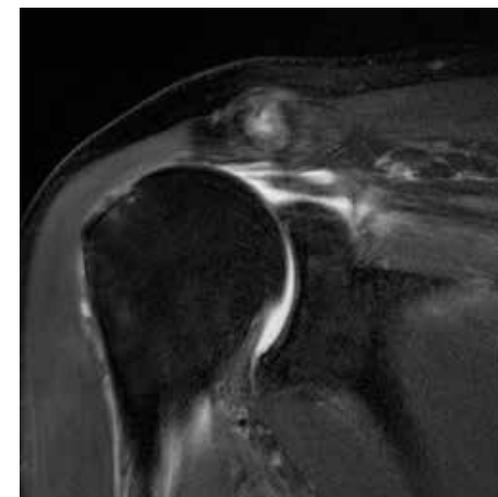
A) MRI image demonstrating superior inclination of the glenoid
